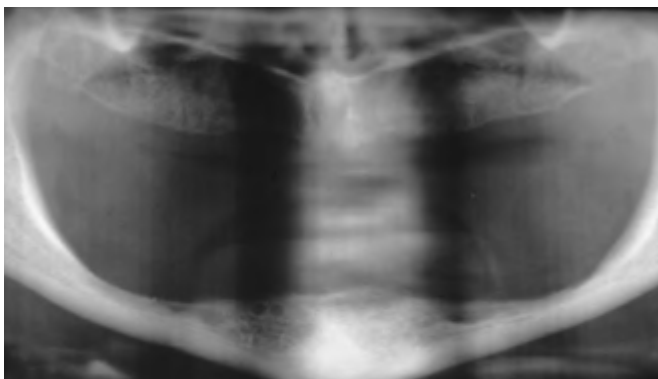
Preoperative panoramic radiograph that demonstrated the patient's edentulous jaws. There was adequate mandibular bone height and width to potentially accommodate dental implants in the anterior mandible.
